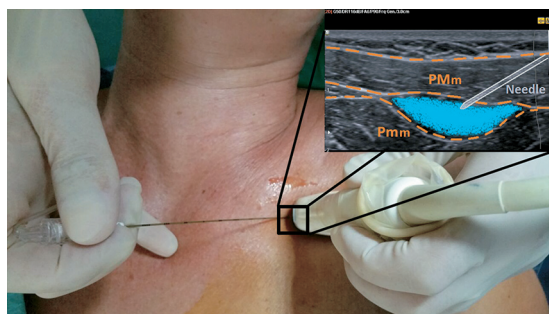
Ultrasound-guided PECS I Block. PMm: pectoral major muscle; Pmm: pectoral minor muscle.
